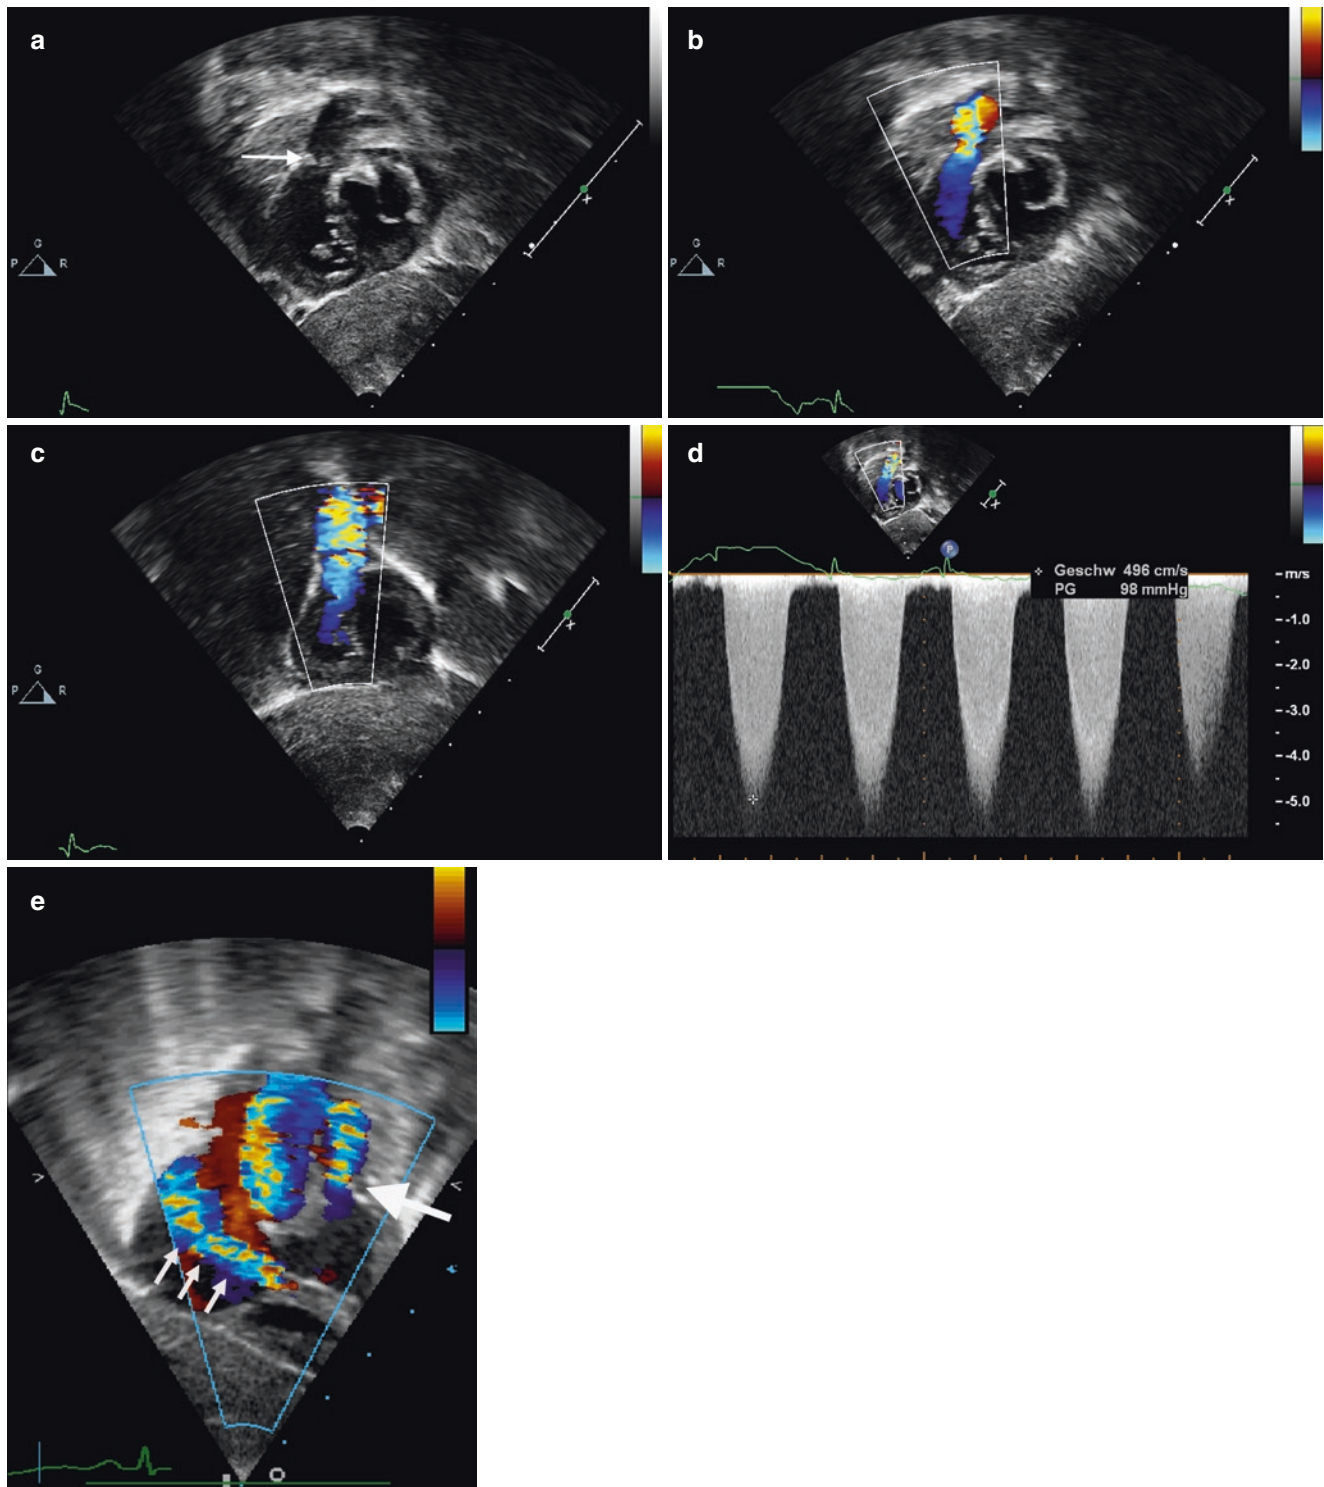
Diastolic frame (a) of the normal tricuspid pulmonary valve in a neonate (high left parasternal short axis view); normal separation of the valve leaflets in systole (b). The stenotic bicuspid pulmonary valve
